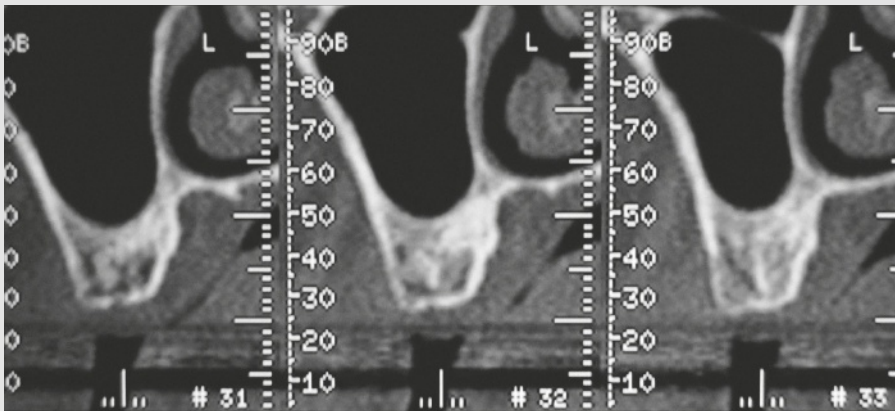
Right sinus view before treatment; CBCT coronal section.
